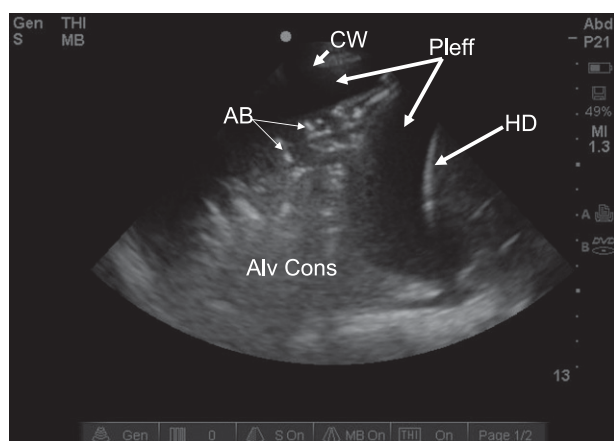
Alveolar consolidation with pleural effusion. Longitudinal scan midaxillary on right. Notice ultrasonographic hepatization of airless lung with punctate areas of white representing air bronchograms. AB = air bronchogram. See Figure 2 legend for expansion of other abbreviations.
